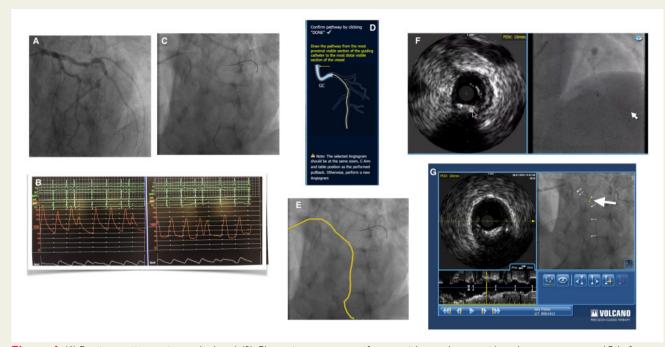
Figure I (*A*) Previous angiogram image displayed. (*B*) Change in pressure waveform on right panel upon guide catheter engagement. (*C*) Left anterior descending artery wired using the previous angiogram as a roadmap. (*D* and *E*) Percutaneous transluminal coronary angioplasty wire used to mark vessel course. (*F*) Intravascular ultrasound pull back performed. (*G*) Intravascular ultrasound co-registration performed by the software, yellow marker (white arrow) corresponds to intravascular ultrasound image.
